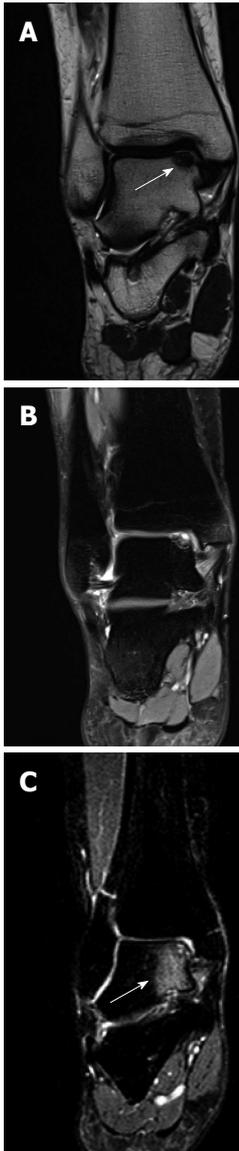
Magnetic resonance imaging scans of coronal T1 (A) and T2 (B) and bone edema on a T2 image (C). Coronal T1 (A) and T2 (B) magnetic resonance imaging scans of a right ankle with an osteochondral lesion of the medial talar dome. Note that the extent of the bony defect is difficult to assess precisely due to the bone edema on a T2 image (C).
